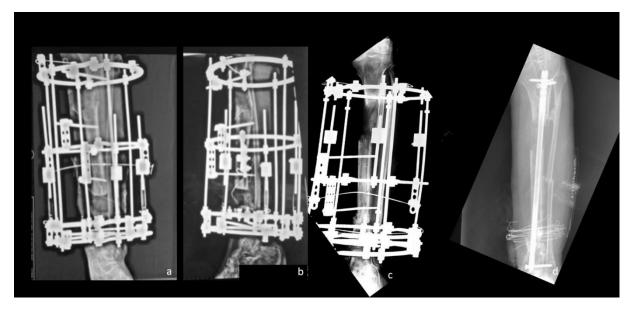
A clinical case showing the proposed treatment. In *a*) and *b*) anteroposterior and lateral X-rays during bone transport; *c*): docking point nonunion; *d*): intramedullary nailing of the docking point non-union.
